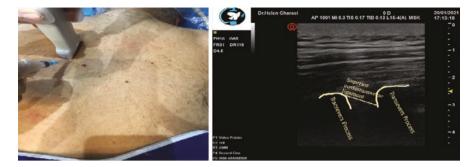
Ultrasound-guided thoracic paravertebral (between the T2 and T3). After passing the ligament, inject drug
